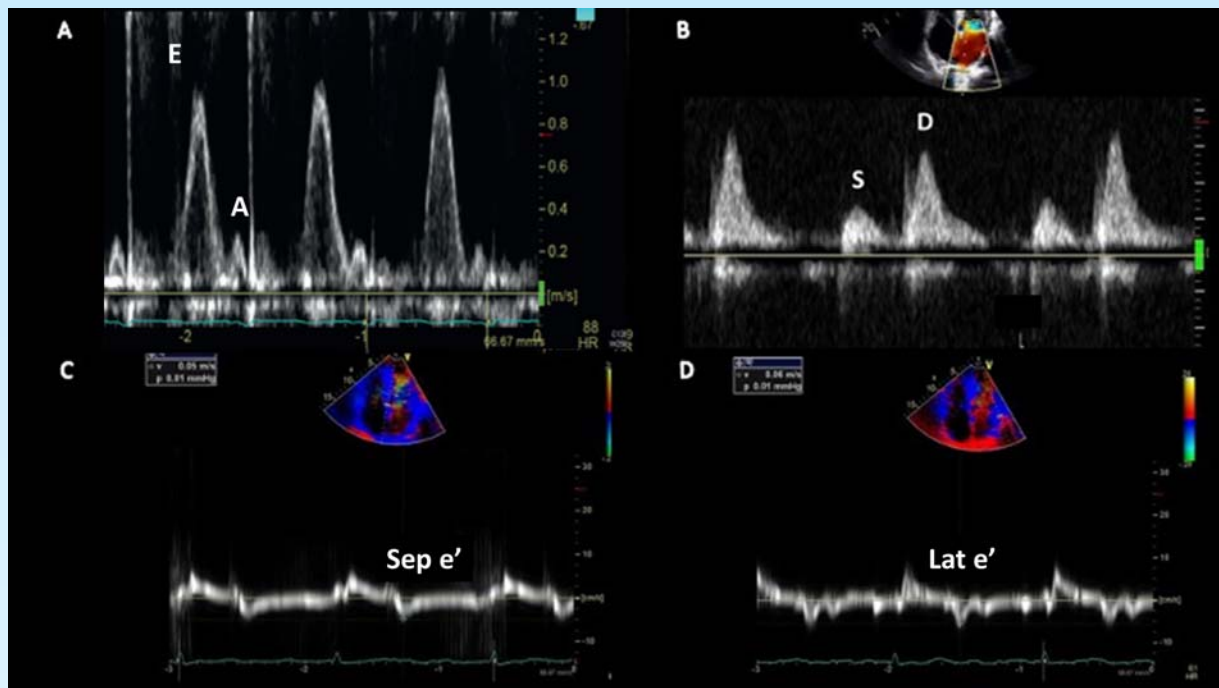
Typical Doppler velocity waveforms in amyloidosis. (A) Mitral inflow demonstrates a high E-wave velocity with a small A-wave velocity,  $E/A > 2$ , and short deceleration time of 100 msec. (B) Pulmonary vein velocities exhibit systolic (S) blunting. Mitral annular tissue Doppler imaging velocities at the septal (C) and lateral (D) aspects of the annulus are reduced, leading to an average  $E/e' > 14$ . Sep  $e'$  = septal  $e'$  velocity, Lat  $e'$  = lateral  $e'$  velocity.
